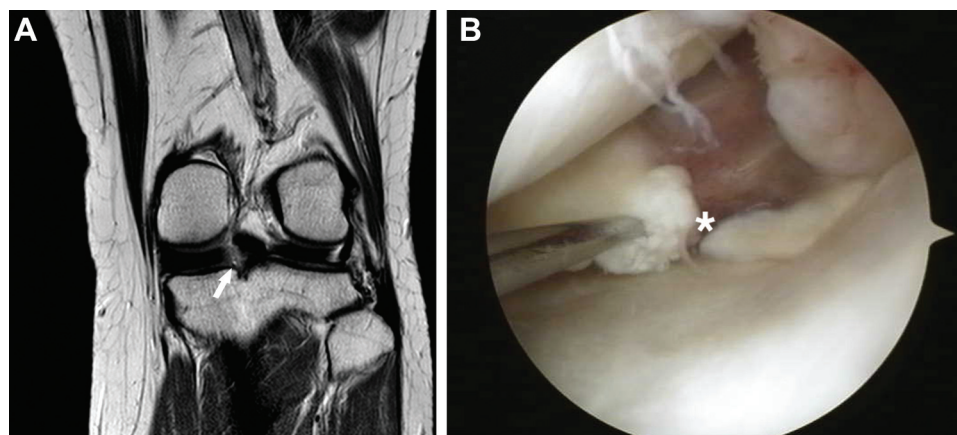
(A) Coronal fat-saturated T2-weighted image showing a root tear of the medial meniscus (arrow) and (B) arthroscopic view showing the posterior root tear of the medial meniscus (asterisk).
